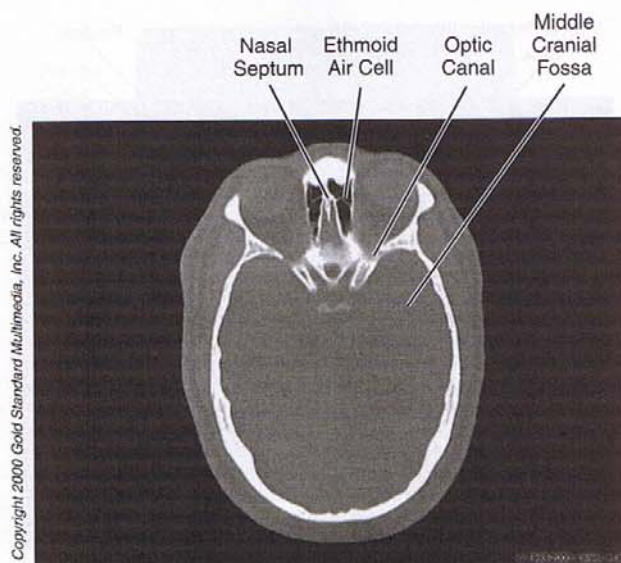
Head and Neck: CT, Skull
